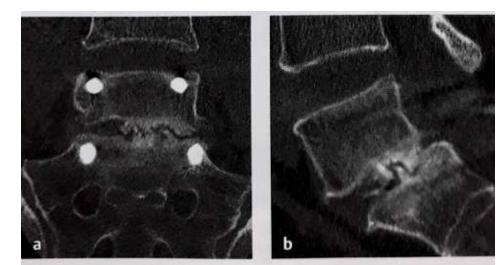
(a, b) CT images showing intradiscal gas shadows at L5–S1 with implants in situ, indicating pseudoarthrosis.
